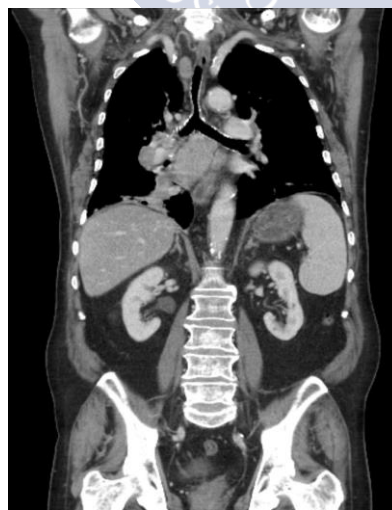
CT image of the human body, granted by the Department of Radiology, University Hospital, Santiago de Compostela. The image corresponds to a patient with lung carcinoma. High-density tissues (i.e. bone) appear bright due to high attenuation of the X-ray beams, while low-density tissues (i.e. lung) appear dark.
